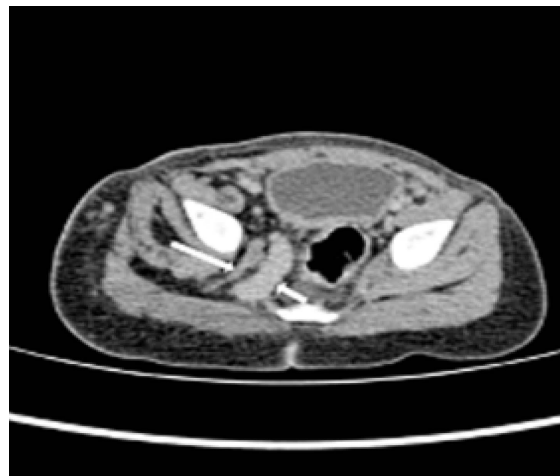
Axial CT scan of the pelvis showing infiltration of the enhancing right superior gluteal vein (short arrow). The linear structure anterior to it represents an enlarged right superior gluteal vein (long arrows).
